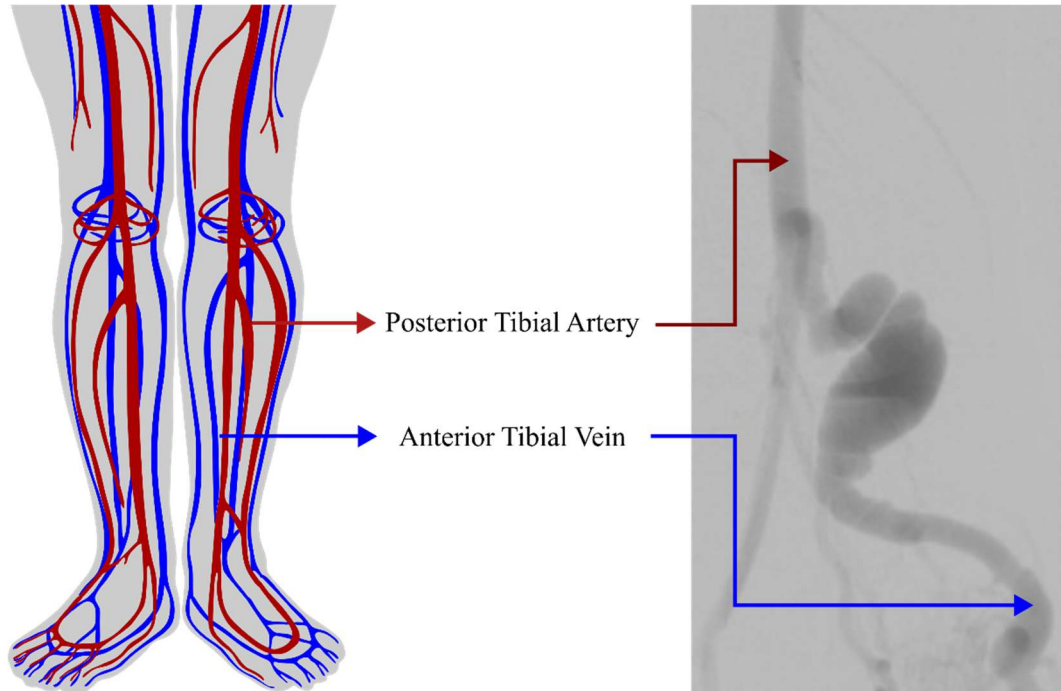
Arteries and veins of the lower legs (left) (Lezak & Varacallo, 2022) and patient CT scan derived from the DGMC (right)
